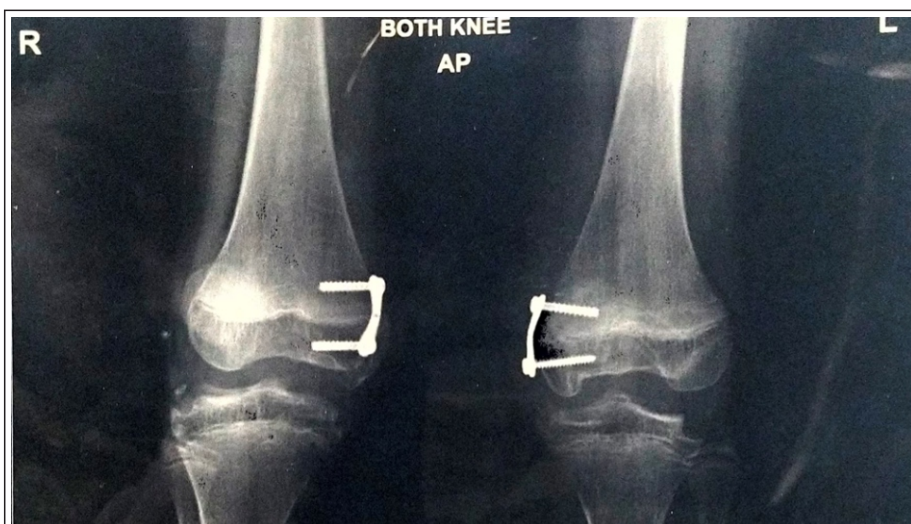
(a and b) X-rays at 5-years follow-up.
